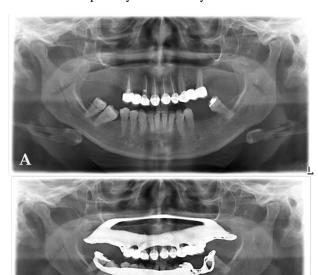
(A) Orthopantomograph after cementing fixed partial denture in maxillary arch in place (B) Orthopantomograph after placing both mandibular and maxillary cast partial dentures
